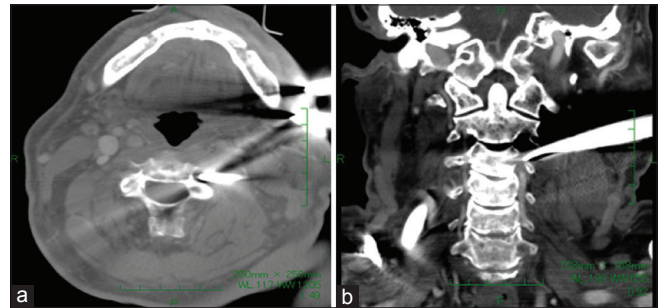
(a) A plain computed tomography (CT) scan (axial view) indicated vertebral artery injury. (b) An enhanced CT scan (coronal view) demonstrated left vertebral artery interruption
